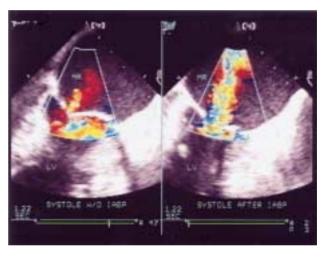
Case 2. Transesophageal echocardiography (2-chamber vertical view) on day 6. Color Doppler flow mapping of mitral regurgitation (MR). On the left: MR without intra-aortic balloon pump. On the right: MR following intra-aortic balloon deflation. LV = left ventricle.
